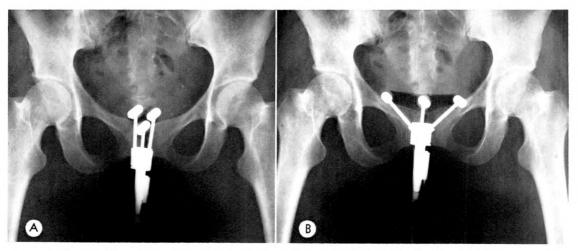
Roentgenograms demonstrating intravaginal insertion of triovoid applicator.
